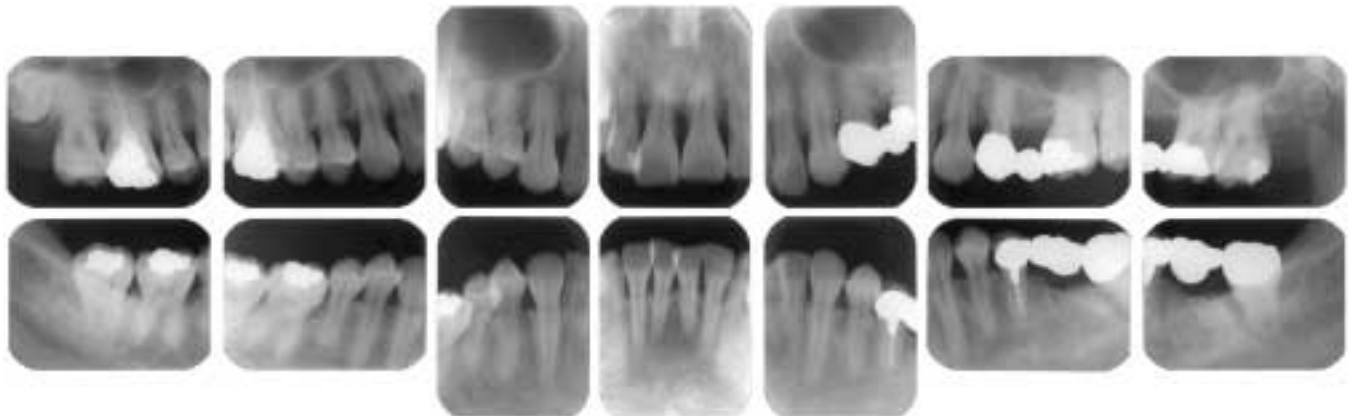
Radiographs at initial visit.
